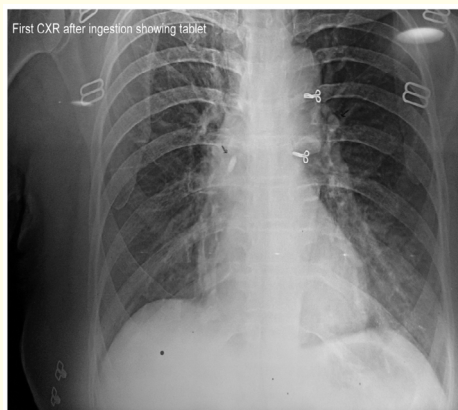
First chest x-ray showing foreign body (iron pill) in right lung.
